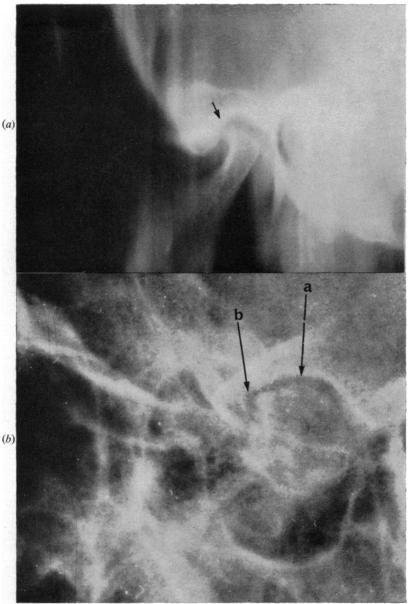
Examples of X-rays of condyles; above, sharply angulated head with flattened surface; below, ill-defined head. (a) Loss of joint space. (b) Suggestion of lipping.
